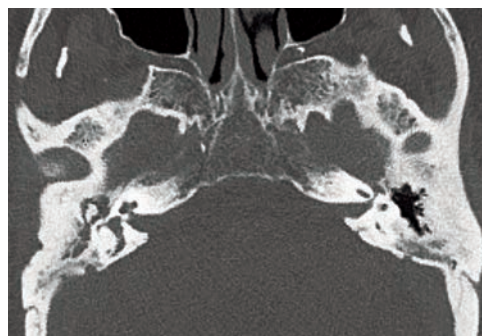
CT temporal bone (axial, sagittal and coronal). Extensive soft tissue density is seen opacifying the right external auditory canal and right middle ear cavity associated with bony erosions of the right mastoid air cell and right middle ear ossicles. The soft tissue opacification is seen extending to the epitympanum with erosion of the right scutum. Rarefaction of the right tegmen tympani (marked by red arrows). Unremarkable left external and middle ear.
